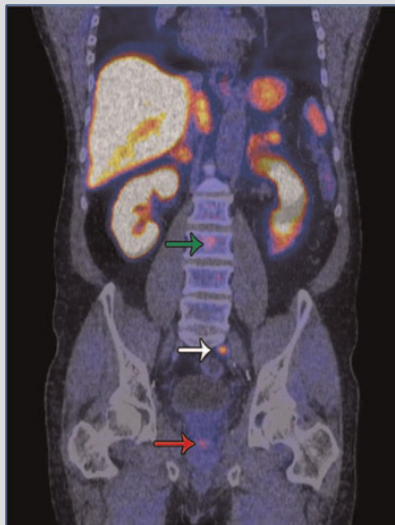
PET/CT image acquired after injection of ^{11}C -choline in a patient with prostate cancer. This image shows metastatic involvement of a lymph node (white arrow) and vertebrae (green and red arrow).
